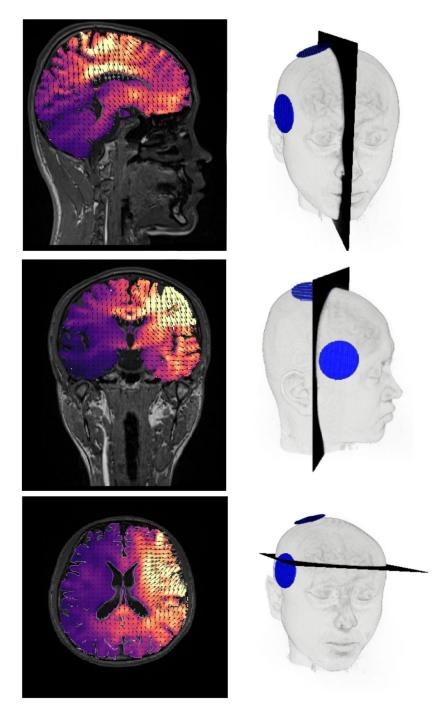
Electrical field on MRI slices to the right. Volume rendering of head with slice and electrodes to the left. Visualization created for this project.
